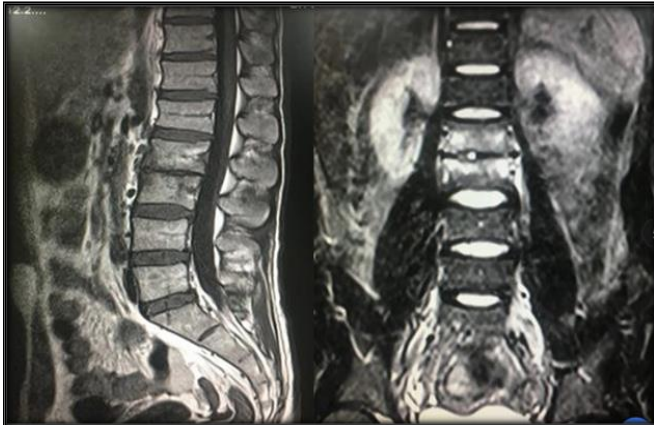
A 27 year male presented with chronic back pain, mild fever and weight loss. MRI shows altered signal intensity at contiguous end plates of L2 and L3 vertebral bodies mostly at peridiscal margins with reduced intervening L2-L3 intervertebral disc height. Posterior appendages are intact. No spine canal encroachment is seen.
